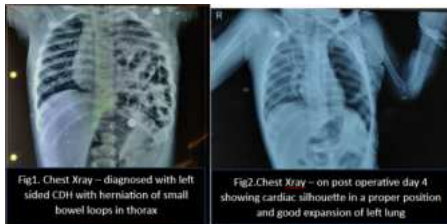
Chest Xray – diagnosed with left sided CDH with herniation of small bowel loops in thorax
